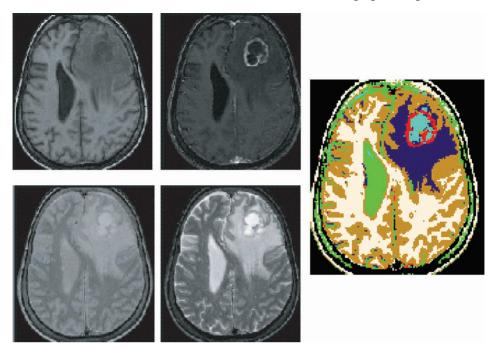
Classification and sub-typing of tumour components based on four MRI modalities. The four MRI images are, clockwise from top left: T1-weighted, T1-weighted following administration of gadolinium-DTPA, T2-weighted and proton-density-weighted. The colour image shows a 6-tissue-class classification based on these four input images, with white =white matter; brown = grey matter; green = cerebrospinal fluid; purple = oedema; red = enhancing ring; turquoise = necrotic centre.
